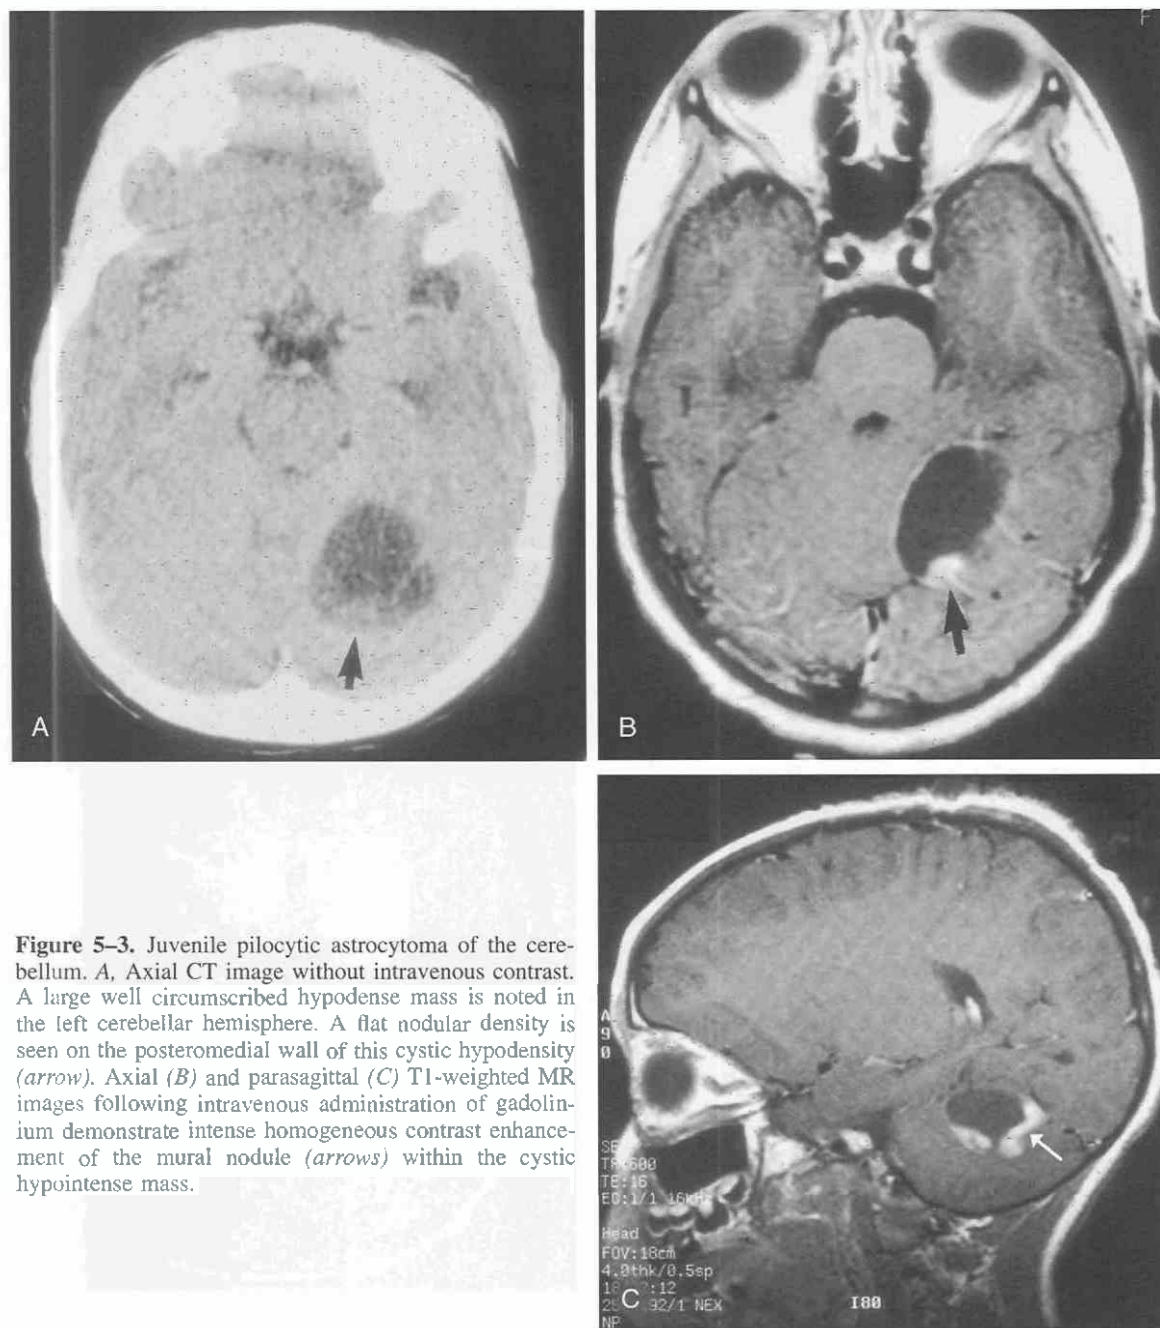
Juvenile pilocytic astrocytoma of the cerebellum. A, Axial CT image without intravenous contrast. A large well circumscribed hypodense mass is noted in the left cerebellar hemisphere. A flat nodular density is seen on the posteromedial wall of this cystic hypodensity (arrow). Axial (B) and parasagittal (C) T1-weighted MR images following intravenous administration of gadolinium demonstrate intense homogeneous contrast enhancement of the mural nodule (arrows) within the cystic hypointense mass.
